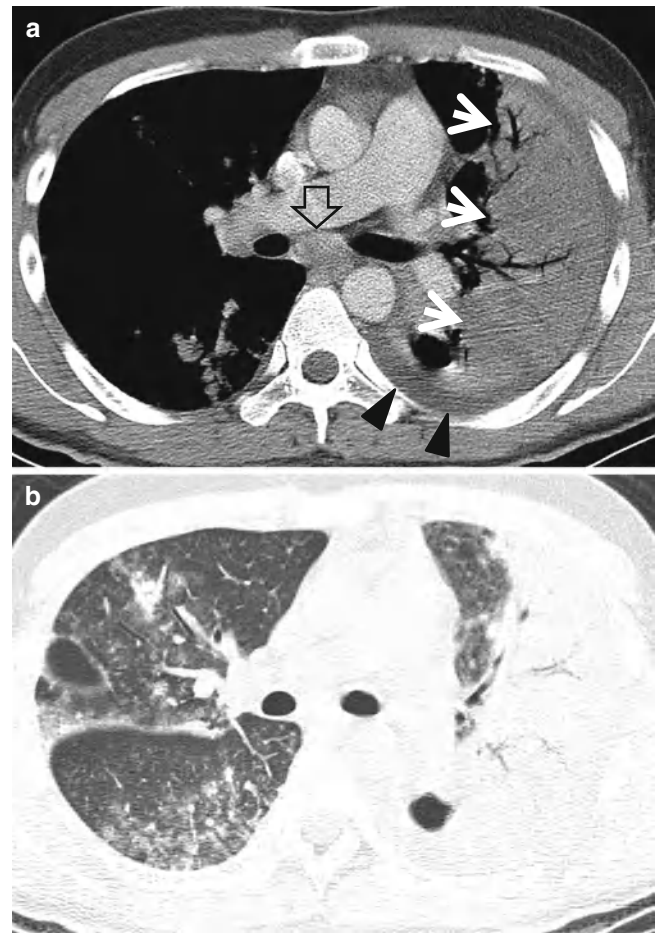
Lobar consolidation as a manifestation of pulmonary tuberculosis in a 24-year-old man. (a) Mediastinal window of enhanced CT scans (5.0-mm section thickness) obtained at level of main bronchi shows lobar consolidation (arrows) in left upper lobe. Some parenchymal lesions are also seen in right lung. Note enlarged subcarinal lymph node (open arrow) and left pleural effusion (arrowheads). (b) Lung window image obtained at the same level to a demonstrates findings of tree-in-bud signs and small nodules in contralateral right lung suggestive of bronchogenic spread of tuberculous pneumonia
